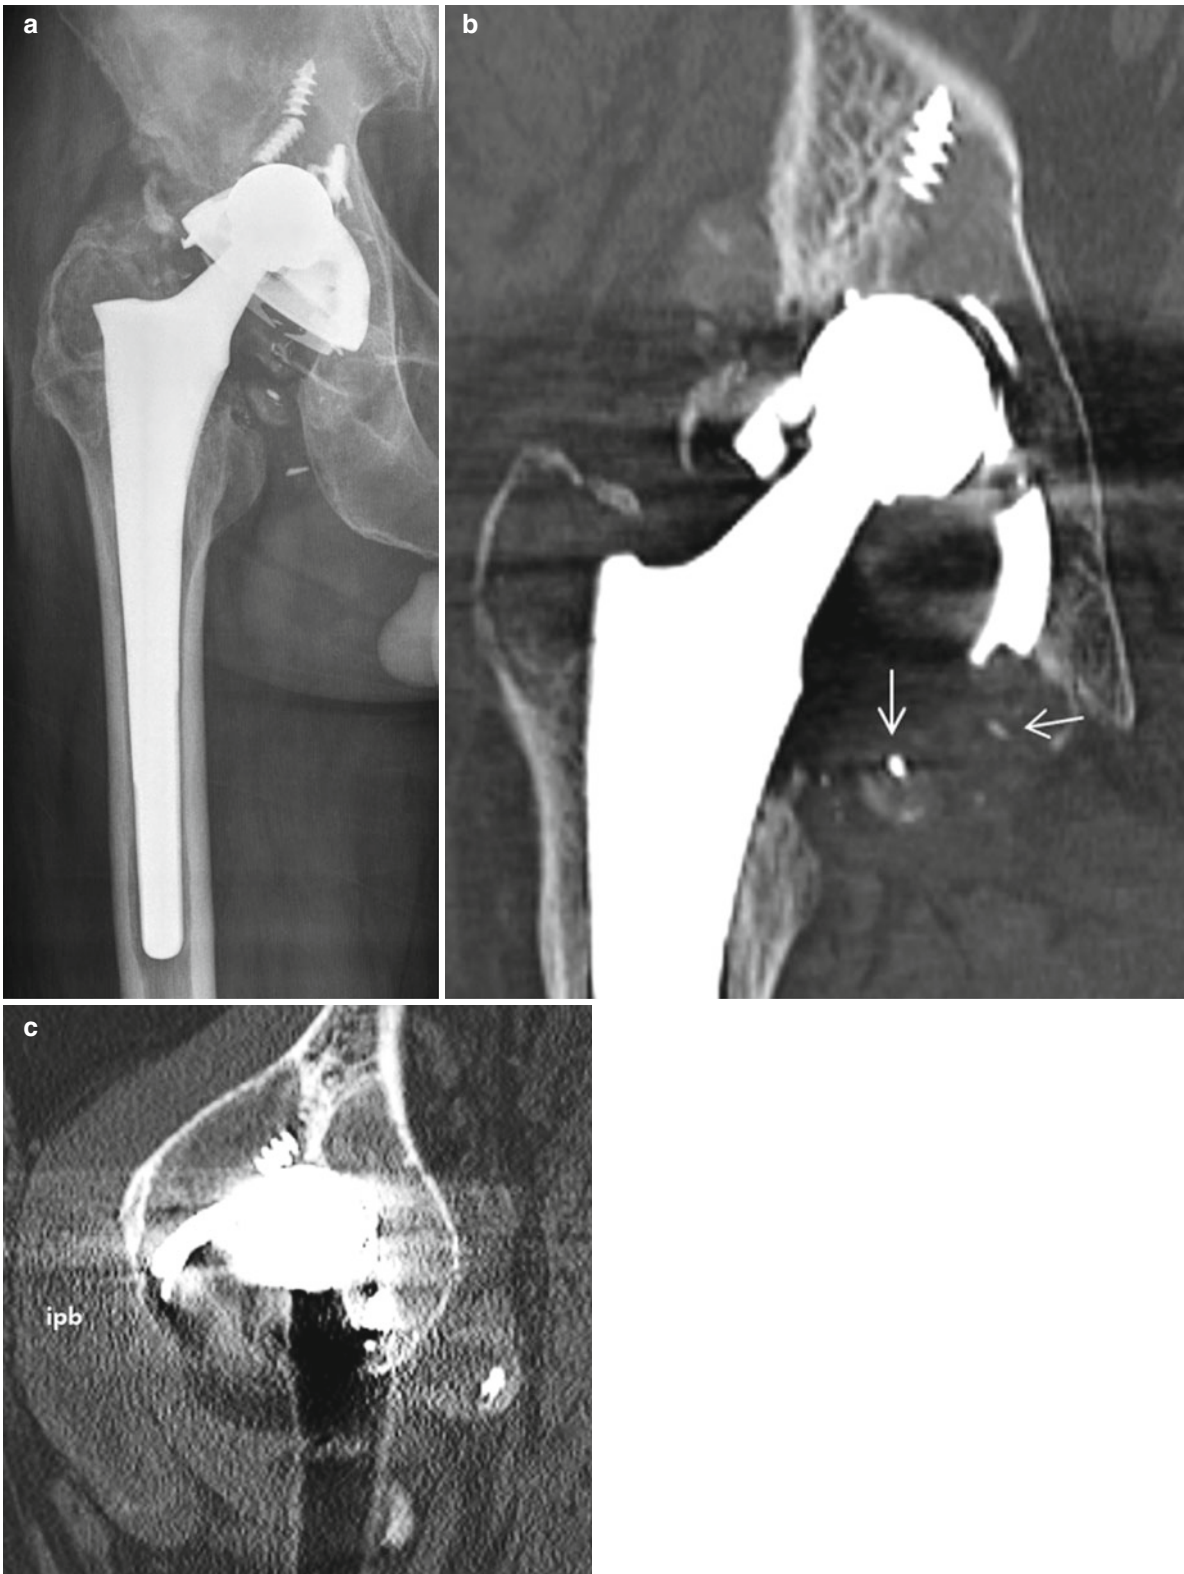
Osteolysis and metallosis with severe wearing of polyethylene liner in a 60-year-old male who underwent hip arthroplasty 18 years ago. (a) Anteroposterior view of the right hip joint shows relatively well-defined, multilobular osteolytic lesions involving both the acetabular and femoral components, with internal radiodense opacities. Superior migration of the femoral head through the defect of acetabular cup and polyethylene liner is noted. (b) Coronal reformatted CT image
